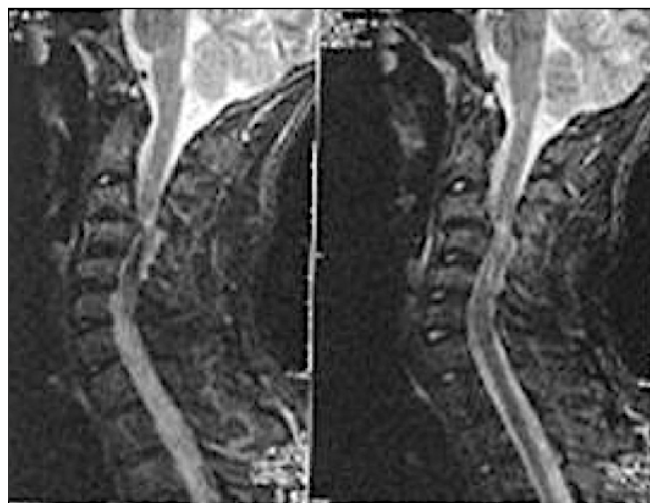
Case no. 2. MRI shows C3 vertebra dislocation
